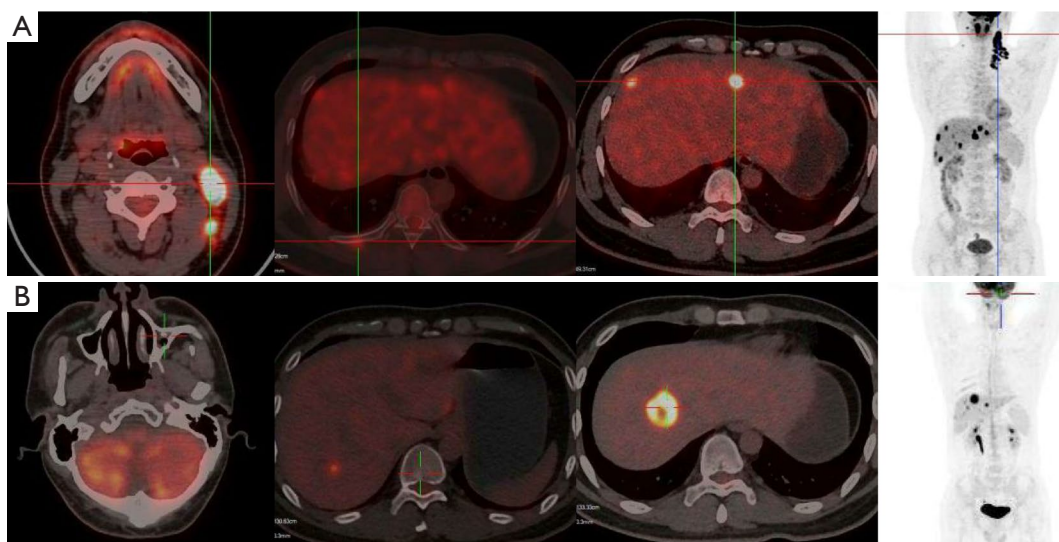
PET/CT scan at baseline (A) and one month after initial immune checkpoint inhibitor treatment combined with chemoradiotherapy (B).
